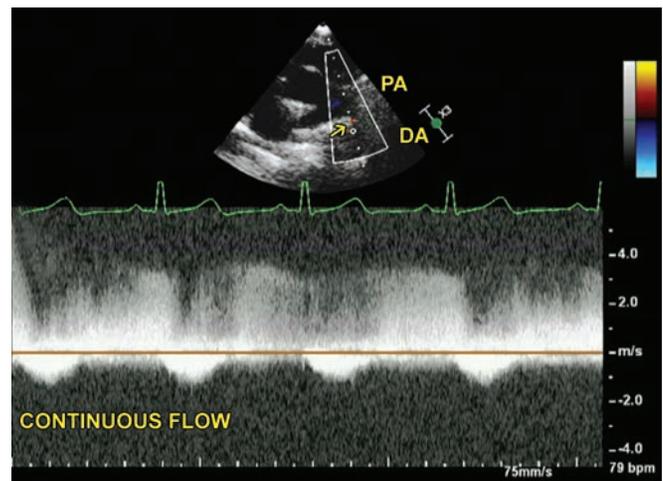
Continuous wave Doppler shows high velocity signals throughout the cardiac cycle typical of PDA.
